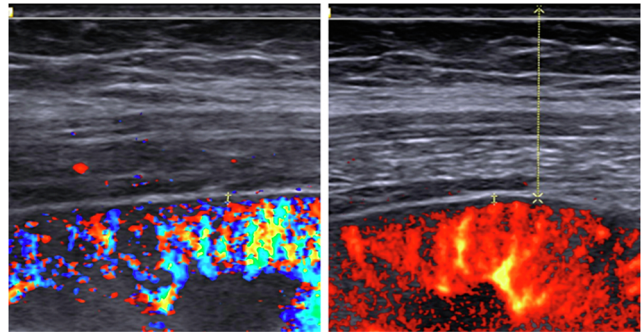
Cortical perfusion quantified as the distance from the renal capsule to the most peripheral detectable Doppler signal, using a linear transducer with color and power Doppler.
